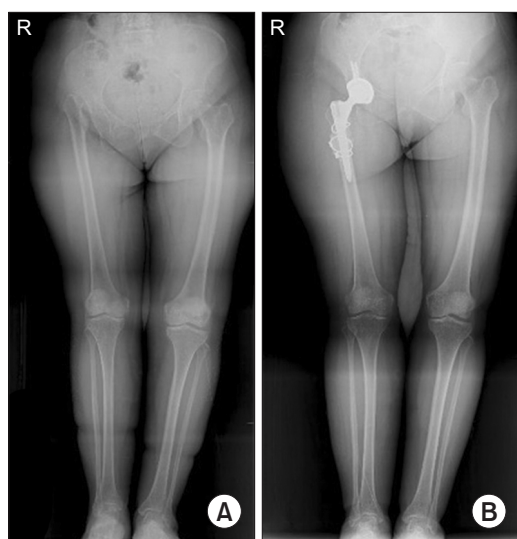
Preoperative (A) and postoperative (B) full-length standing radiographs of patient 5 who underwent femoral shortening osteotomy to achieve reduction.
